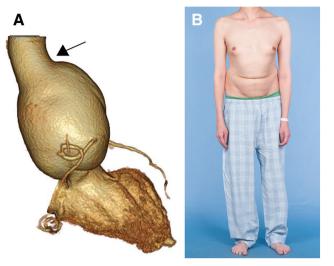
(A) Preoperative volume rendering CT. The aortic root was dilated like a pear. The black arrow indicated the sites collected for pathological examination. (B) Appearance of the patient. In the appearance, humpback and lumbar flexion were recognized.
